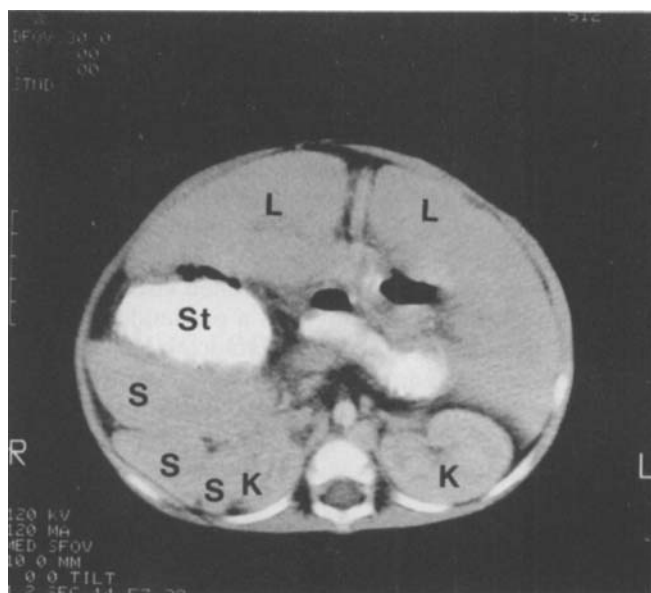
CT of the abdomen of patient 1 revealing a right-sided polysplenia (*S*) compressing the right kidney. *ST* Stomach; *L* large liver; *K* kidneys
